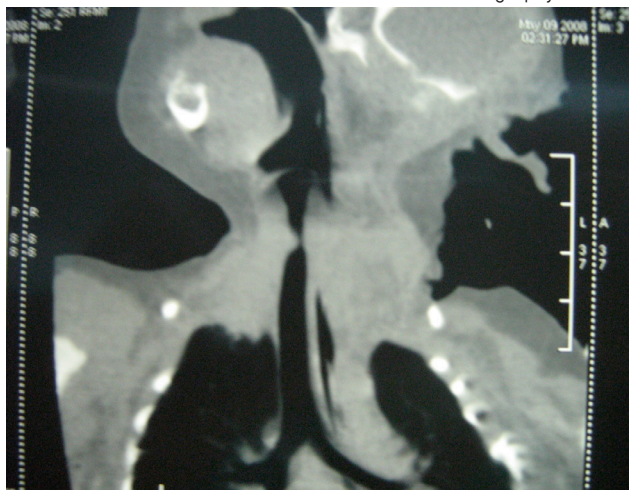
Computed tomography view of subglottic stenosis
